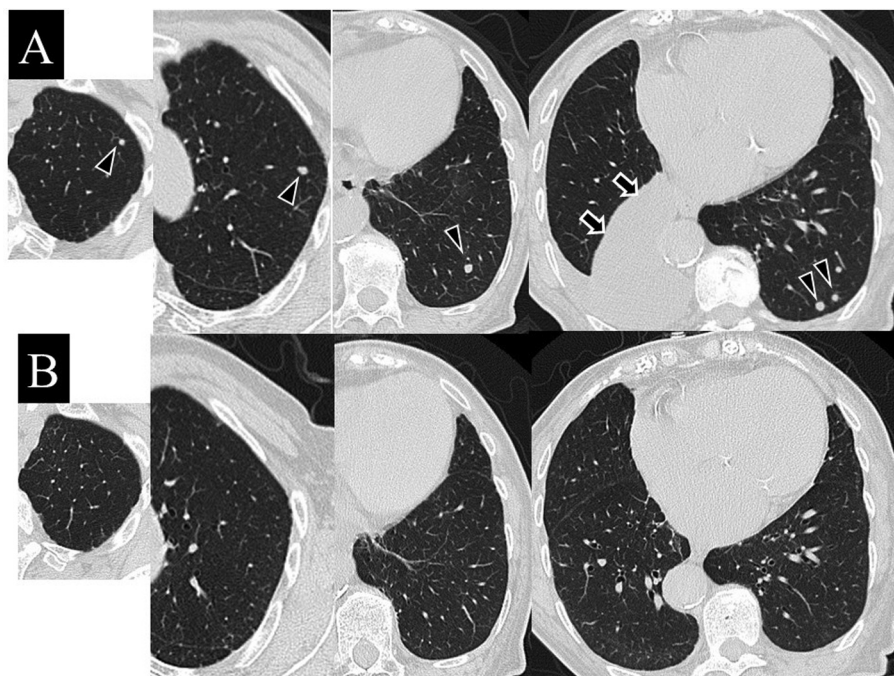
Chest computed tomography of patient 1 taken at the time of the first visit showed a primary lesion in the right lower lobe (arrows) and metastatic lesions in both lungs (arrowheads) (A). Chest computed tomography taken 3 months after starting alectinib showed disappearance of bilateral lung lesions (B).
